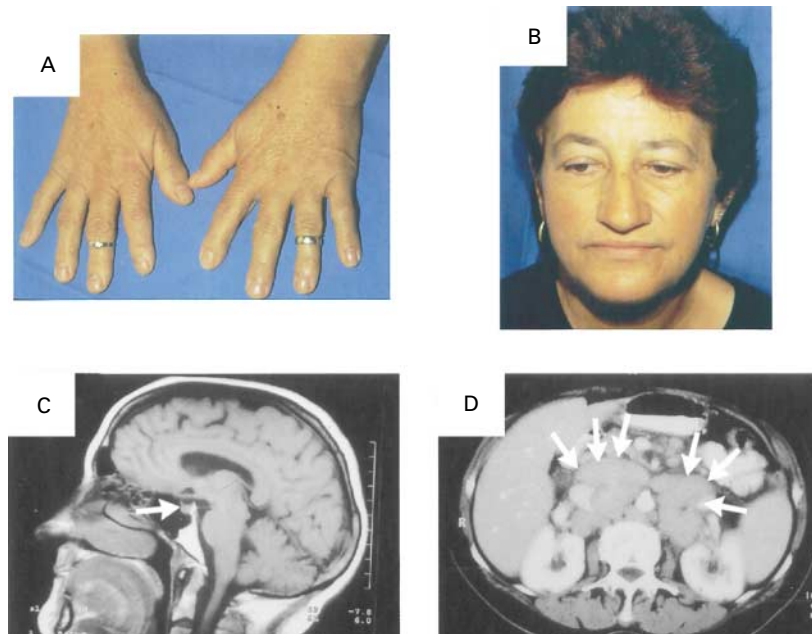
Photographs and Computed Tomographic and Magnetic Resonance Images of a Patient with Acromegaly and Lymphoma.
